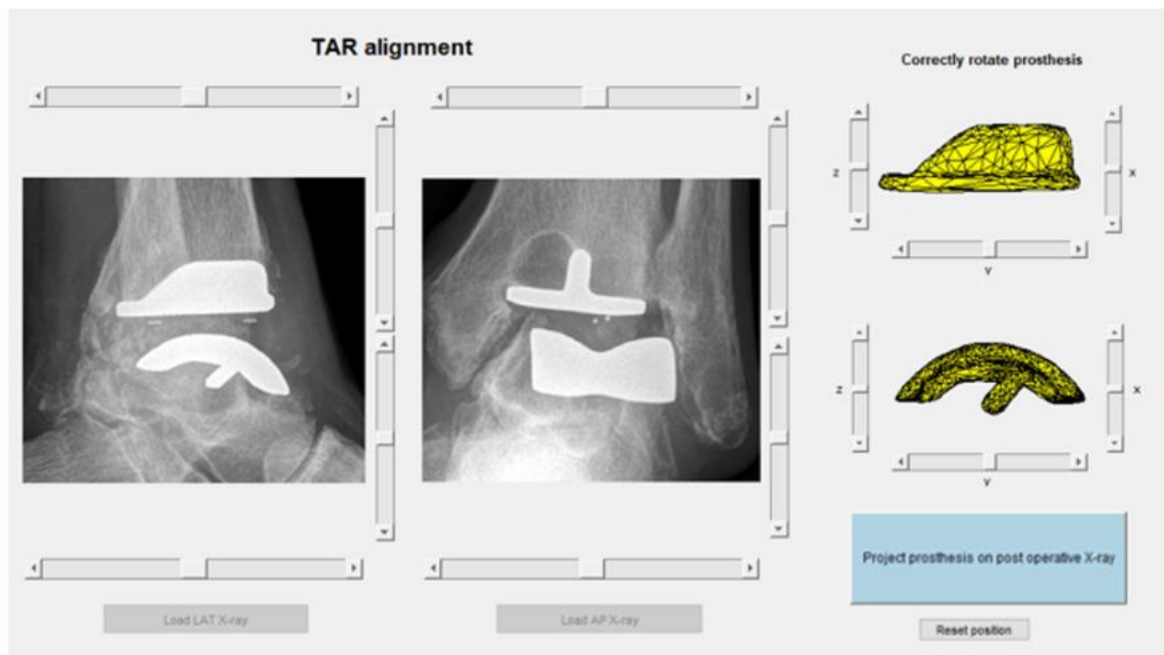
The graphical user interface of the tool displaying the lateral and anteroposterior radiographs (on the left) and 3D reconstructions of the tibial and talar CCI Evolution TAR component (on the right). Sliders around the radiographs to translate the contours of the 3D CCI parts, sliders around the 3D reconstructions to rotate the contours of the 3D CCI parts
